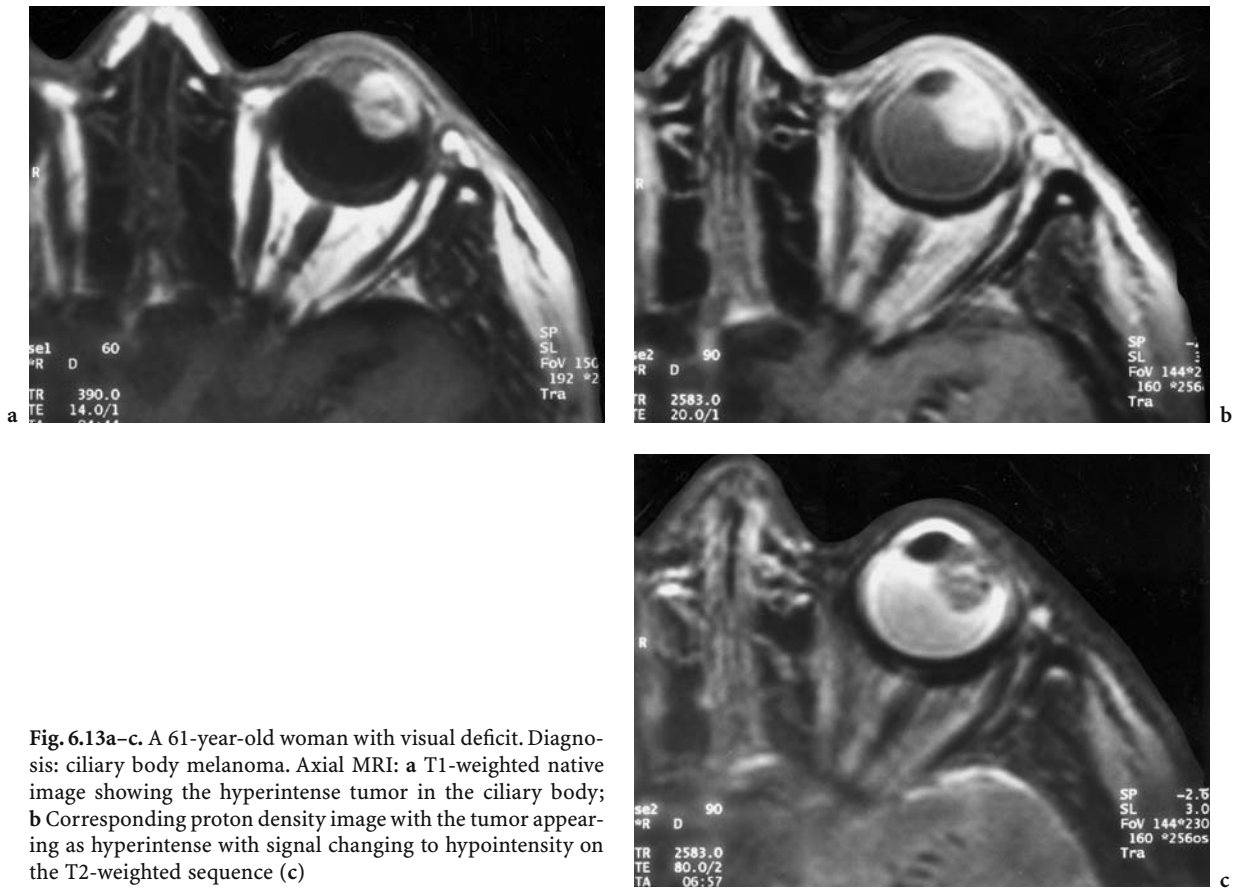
A 61-year-old woman with visual deficit. Diagnosis: ciliary body melanoma. Axial MRI: a T1-weighted native image showing the hyperintense tumor in the ciliary body; b Corresponding proton density image with the tumor appearing as hyperintense with signal changing to hypointensity on the T2-weighted sequence (c)
